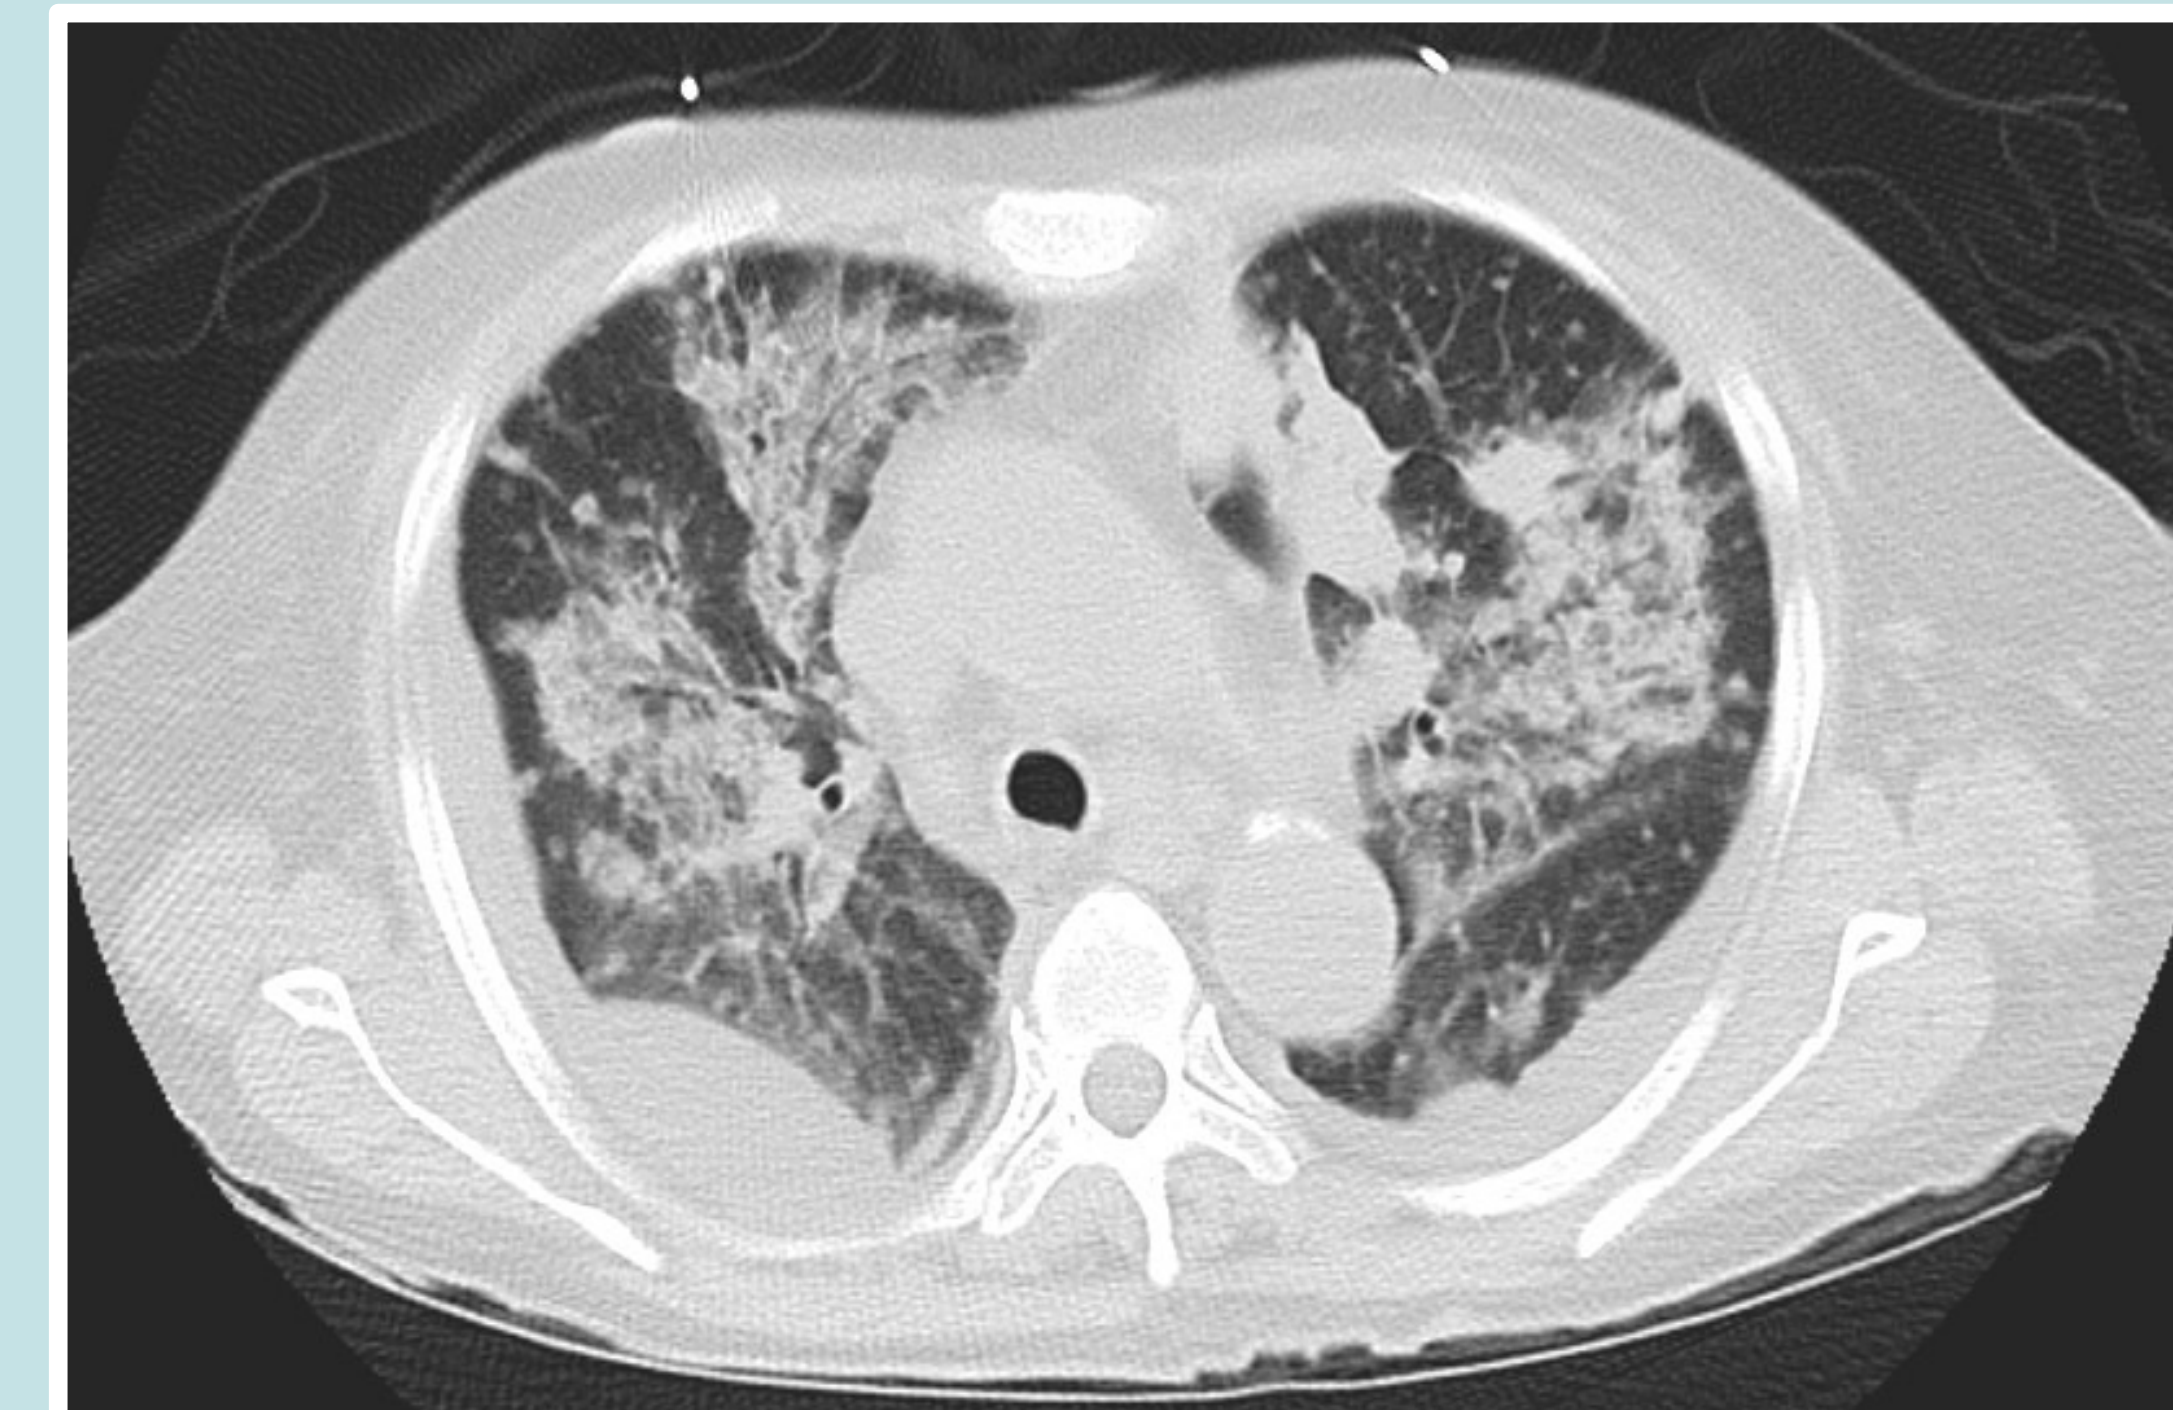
Axial CT chest demonstrating prior nodular opacities and new confluent areas of ground glass opacities with intervening interstitial thickening.
